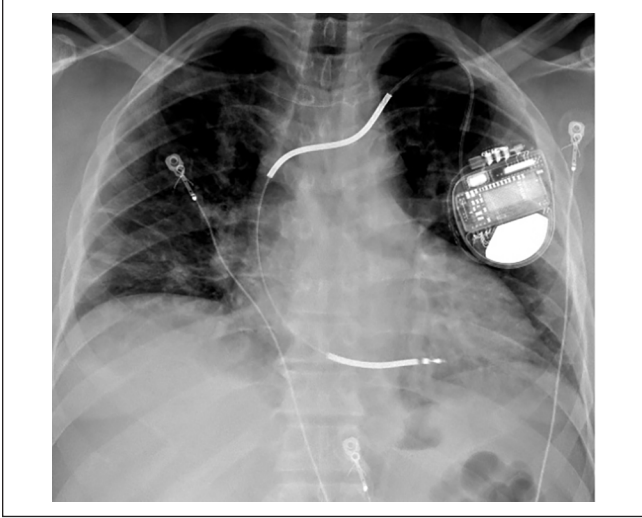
Chest X-ray showing septal bilateral patchy lung infiltrates.
